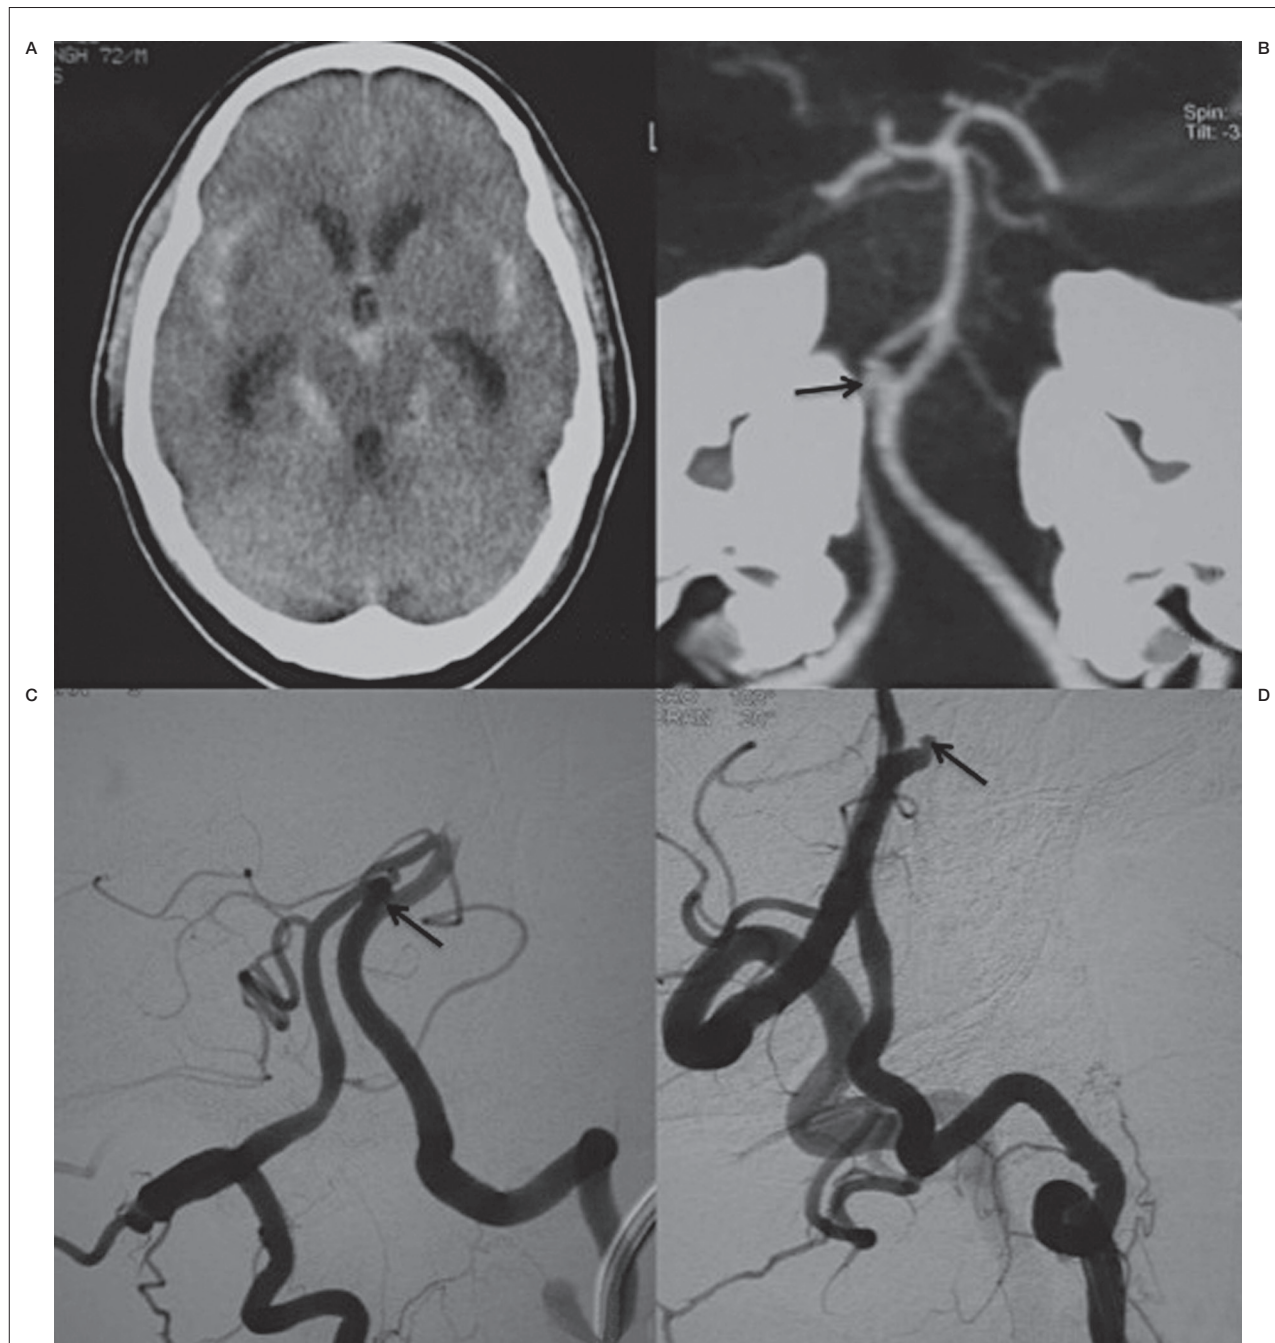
A-D) Patient with left subclavian proximal occlusion and subclavian steal. NCCT (A) showing diffuse subarachnoid hemorrhage with CT angiography image (B) and right vertebral AP (C) and oblique (D) angiogram images showing a saccular aneurysm arising from the proximal bifurcation of the fenestration (arrow in B) with partial incorporation of the left limb (arrow in C). Note a small daughter aneurysm arising from the dome of the aneurysm suggestive of a bleeding point (arrow in D).
